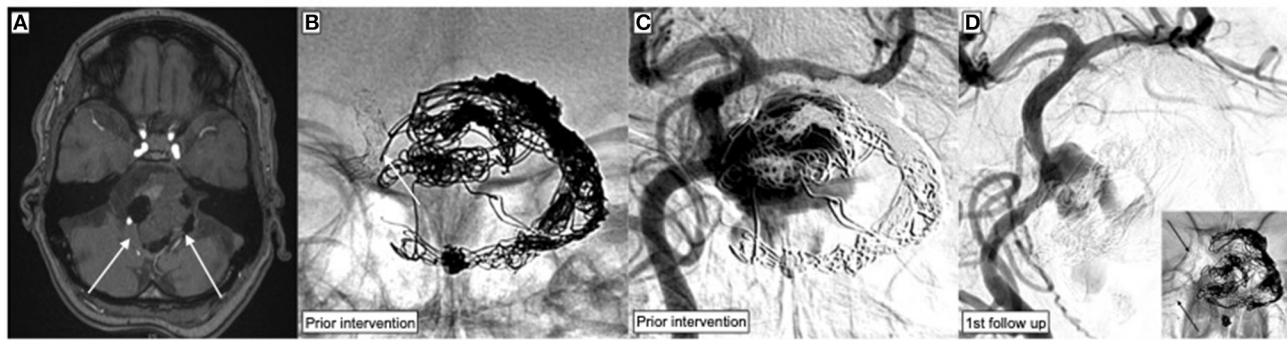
Endovascular treatment of a wide-necked, partially thrombosed giant aneurysm arising from the side wall of the basilar artery, which had been treated with stent-assisted coiling 6 years earlier but without any follow-up. The aneurysm relapsed and caused brain stem compression. (A) Time of flight angiography (TOF) shows the partially thrombosed basilar artery aneurysm (white arrows) compressing the brain stem. (B) Device radiography demonstrates the separation of the previously implanted Neuroform stents (white arrow) and substantial deformation of the coil package. (C) DSA image corresponding to the radiography in (B). The gap between the stents corresponds to the broad neck of the aneurysm. The same projection was used for FDS implantation. (D) The p64MW-HPC was implanted within the Neuroform stents in order to bridge the gap between the separated devices and provide a scaffold for the formation of a neo-intima along the neck of the aneurysm.
